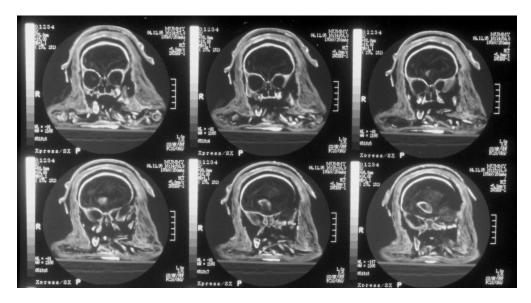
CT-scans of the head of the complete mummified child showing the mask, the abnormal position of the damaged skull and the adult metatarsal in the cranium.
